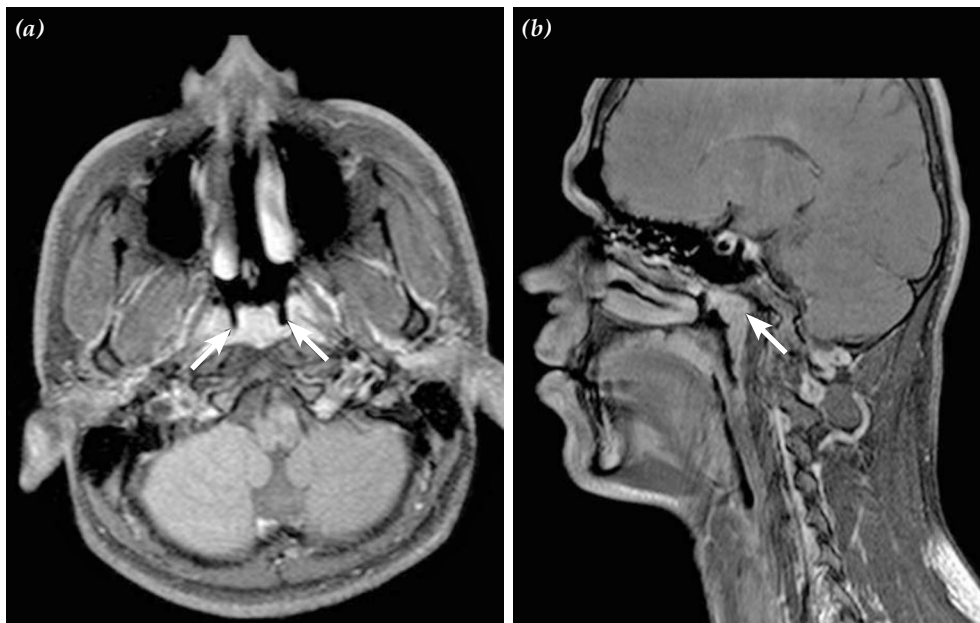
Post-contrast magnetic resonance images in the (a) axial and (b) coronal planes through the nasopharynx. The mass originated from the posterior wall of the nasopharynx, homogeneously enhanced, and protruded into the nasopharyngeal space (white arrows).
